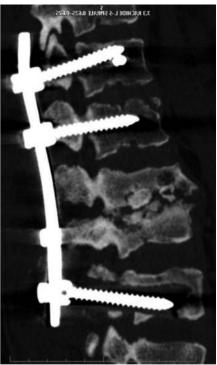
Post-operative X-ray that show T12-L4 instrumentation and L2-L3 decompressive laminectomy, discectomy, curettage and debridement. CT-Scan shows rib allograft placed in L2-L3 disc space.
